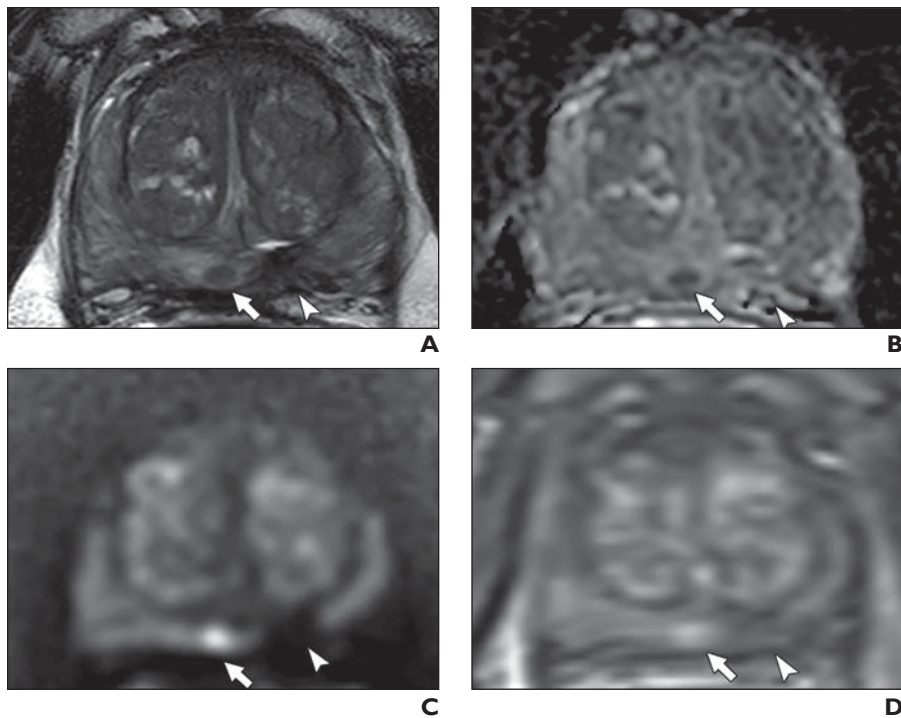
69-year-old man with serum prostate-specific antigen value of 8.38 ng/mL. A–D, Multiparametric MRI (mpMRI) shows band-shaped hypointense signal features (*arrowhead*, A) in left apical–mid peripheral zone on T2-weighted MR image (A), with signal void patterns (*arrowheads*, B and C) on apparent diffusion coefficient map (B) and high-b value DW image (C) without evidence of focal enhancement (*arrowhead*, D) on dynamic contrast-enhanced MR image (D). Findings are consistent with focal laser ablation changes within left apical–mid peripheral zone without evidence of recurrent lesion. Additional finding is seen in posterior midline apical–mid peripheral zone as round hypointense lesion (*arrow*) in A, with corresponding hypointense and hyperintense signal patterns (*arrows*) in B and C, respectively, with focal enhancement (*arrow*) seen in D. Targeted biopsy revealed Gleason 3 + 3 prostatic adenocarcinoma within this lesion.
